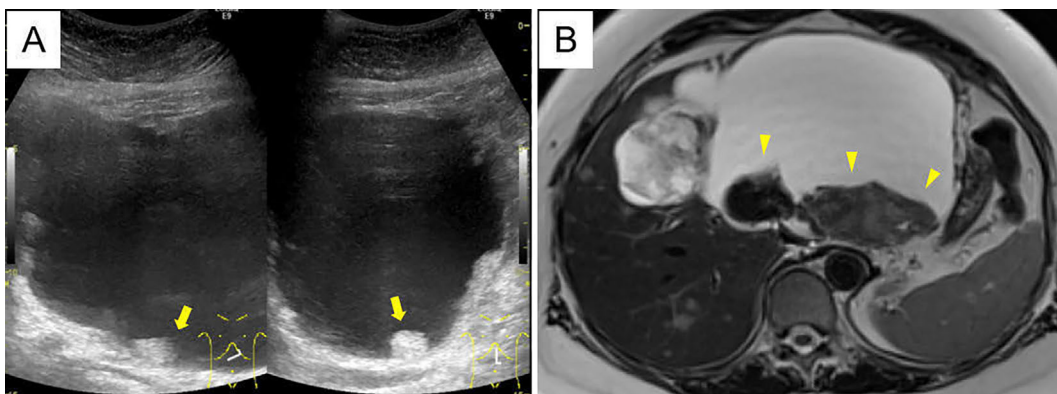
Abdominal ultrasound and MRI-T2. (A) A cystic tumor in the lateral segment of the liver with mural nodules (arrows). (B) A structure in the cystic tumor indicated the presence of precipitated blood clots (arrowheads).
